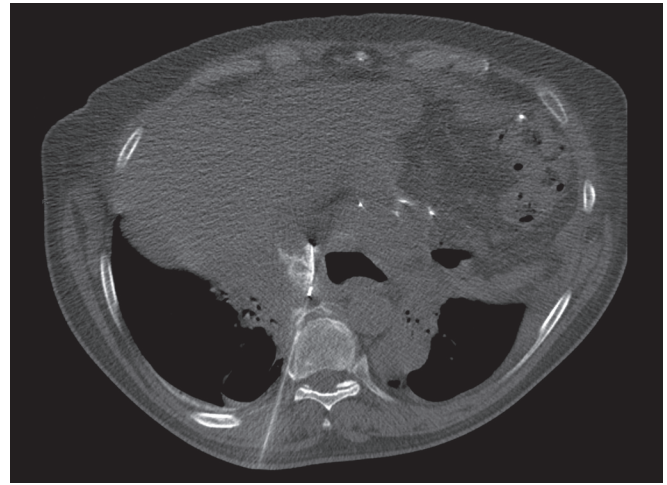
Axial CT showing CT-guided micropuncture and hydrodissection technique demonstrating extrapleural route into mediastinal collection
